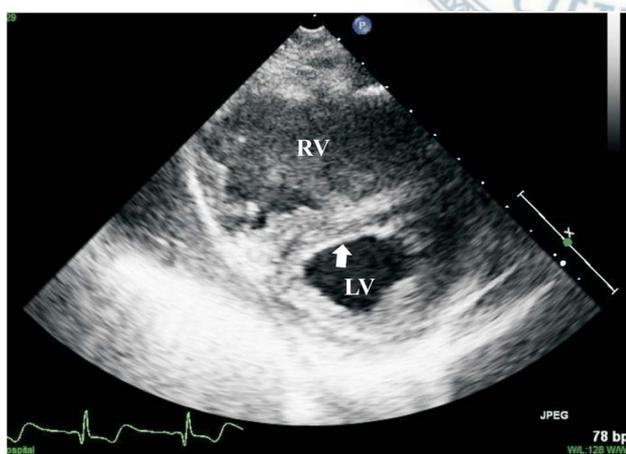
2-D echocardiography of the patient demonstrated marked dilation of right ventricle and a D-shape deformity of the left ventricle during the diastolic phase (white arrow). LV indicates left ventricle; RV indicates right ventricle.
